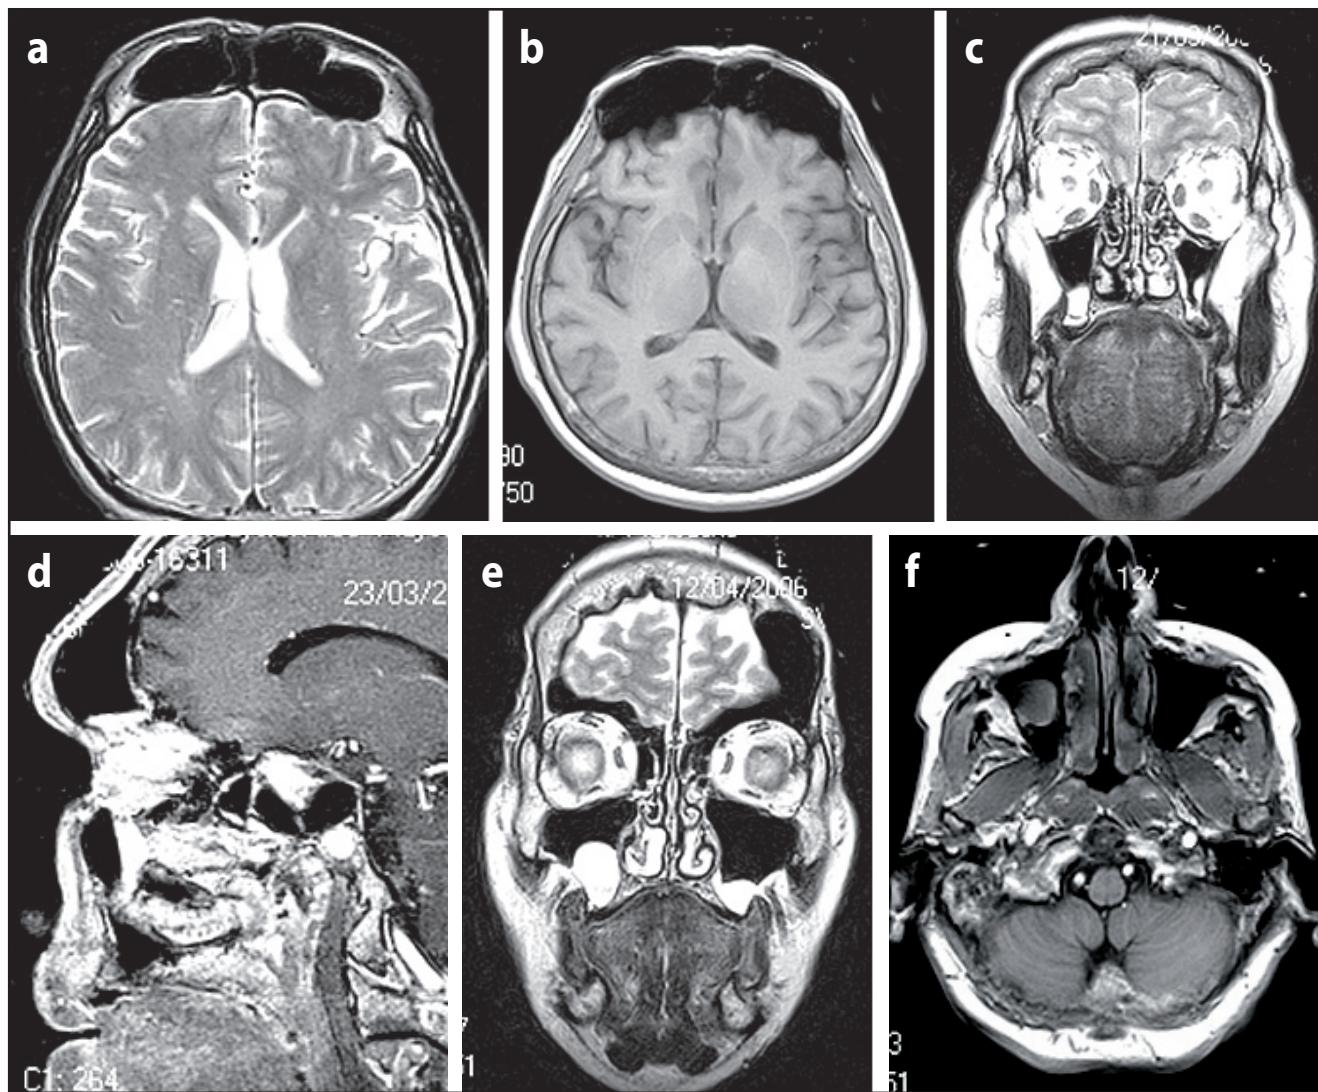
MR images of examined patients. a. Enlarged frontal sinuses; b. Enlarged frontal sinuses; c. Fluid and thickening of mucosa in maxillary sinuses, encysted fluid in sinuses ostia; d. Significant protuberance of the anterior wall, of the frontal sinus and fluid in ostia region, filling material in sphenoid sinus; e. Cysts of maxillary sinuses; f. Cysts of maxillary sinuses.
